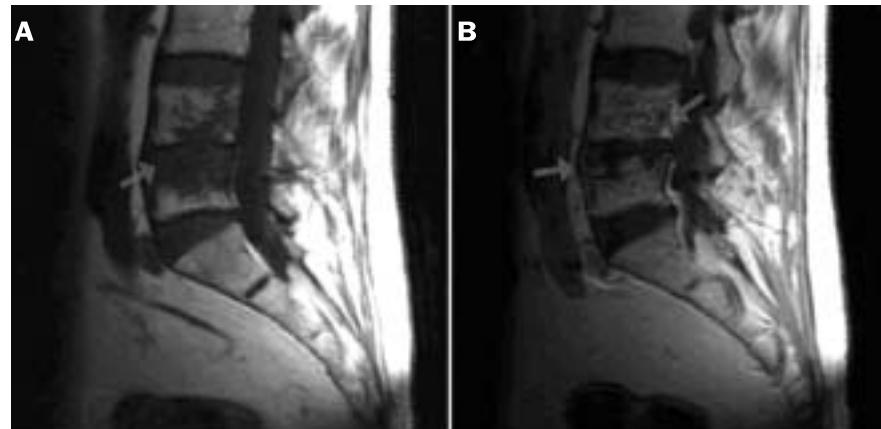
MRI of the lumbar spine showing sagittal T1-weighted image without contrast [A], sagittal T1 [B] weighted images after contrast injection. T1-weighted image without contrast shows decreased signal from the affected vertebral marrow, L4-L5. The cortical definition of the endplates of both vertebrae is lost and there is partial collapse of L5. After injection of gadolinium [B], there is enhancement of the involved vertebrae and the anterior part of the intervertebral disk L4-5.
